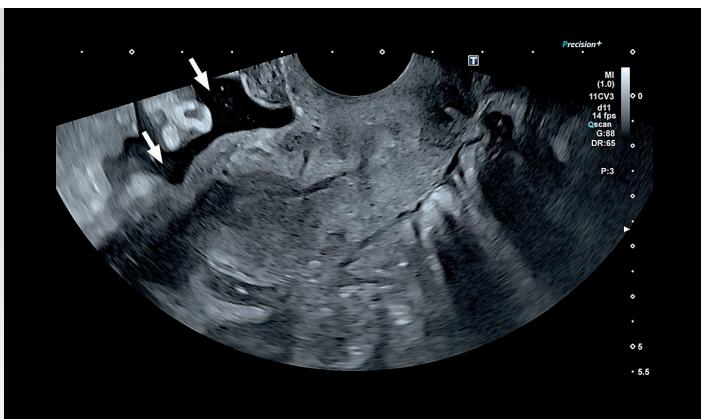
Vigilance! Serial transvaginal scans showed the presence of free pelvic fluid (arrow) with no obvious change in volume in a case of chronic pelvic pain. No adverse features could otherwise be identified by ultrasound or laparoscopy. Biopsy of a normal-looking appendix revealed appendiceal adenocarcinoma with pseudomyxoma peritonei confirmed following further investigation.
